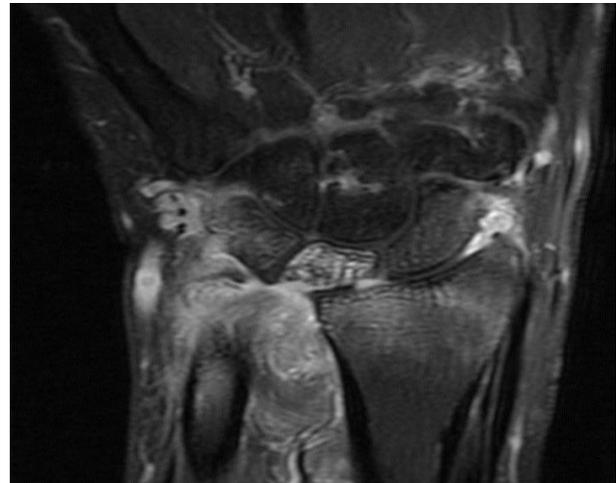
Coronal T2- weighted MR image showing nodular synovial lesion at DRUJ extending to the wrist joint and carpal bones.
